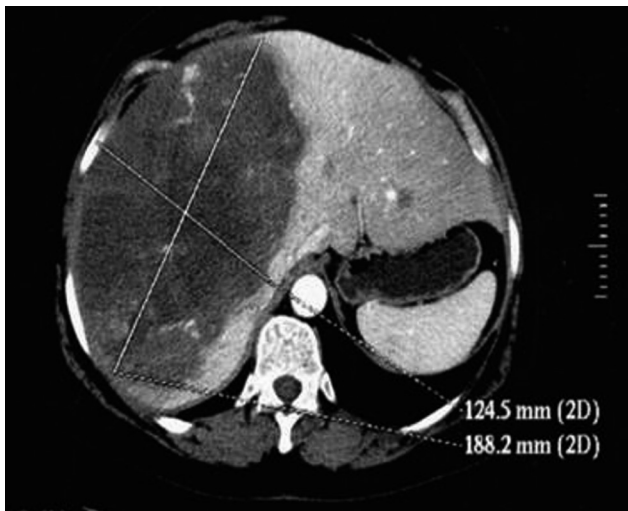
CT scan with early arterial enhancement
